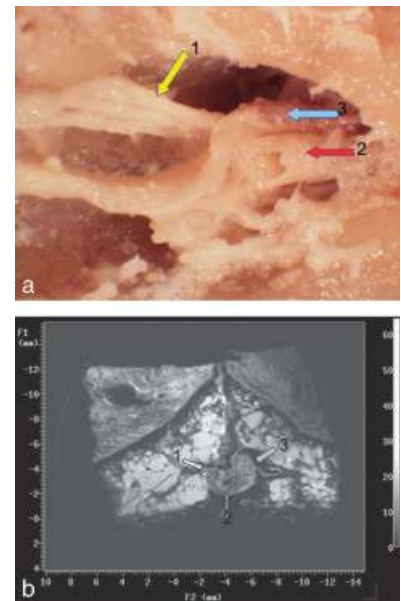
A dissection image (2a) matched with high-resolution magnetic resonance imaging image (2b), both showing the branches of the maxillary division of the trigeminal nerve (arrow 1), the maxillary artery (arrow 2) and the vein (arrow 3) forming the neurovascular bundle of the nasopalatine canal.
